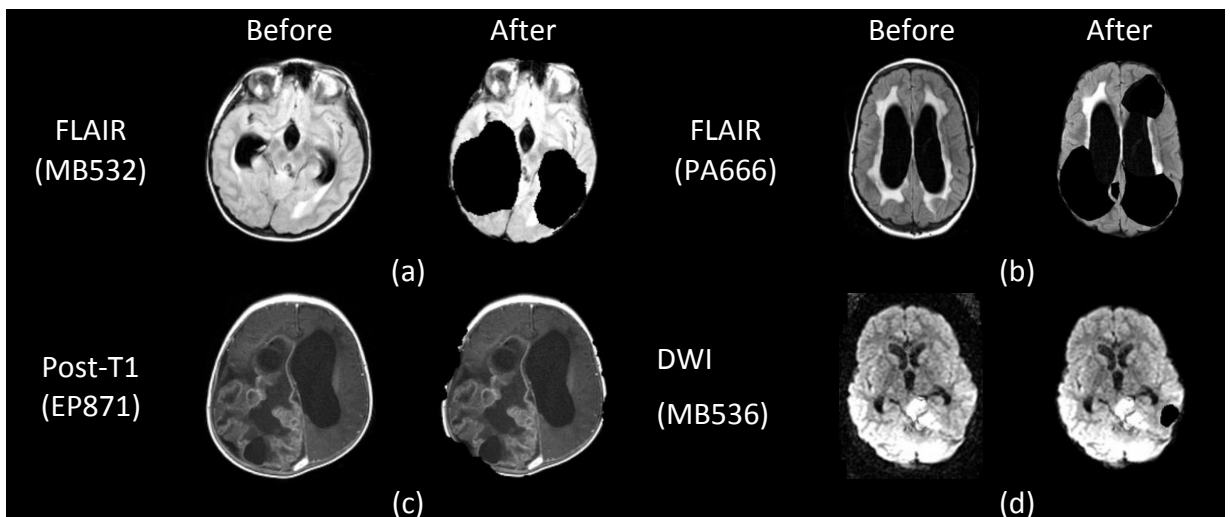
Failure of skull removal on some datasets. The BET method produced hollow regions within the brain tissue on some types of MRI: FLAIR, post-contrast T1 and DWI.
